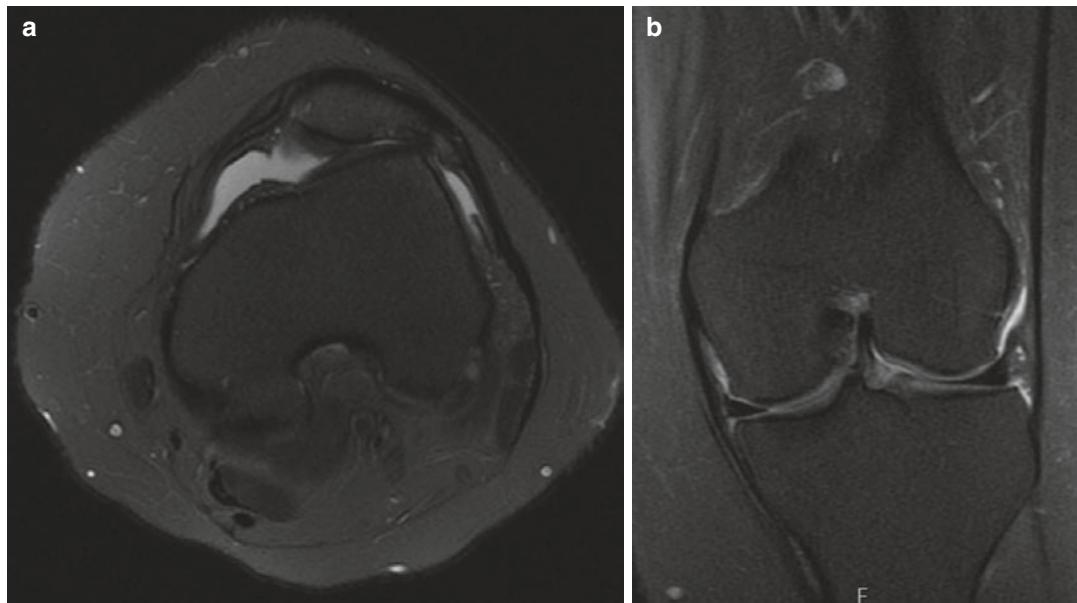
(a) Axial and (b) coronal T2 magnetic resonance imaging (MRI) of the left knee demonstrating lateral patellar tracking, patellofemoral arthritis, and well-preserved tibiofemoral cartilage
